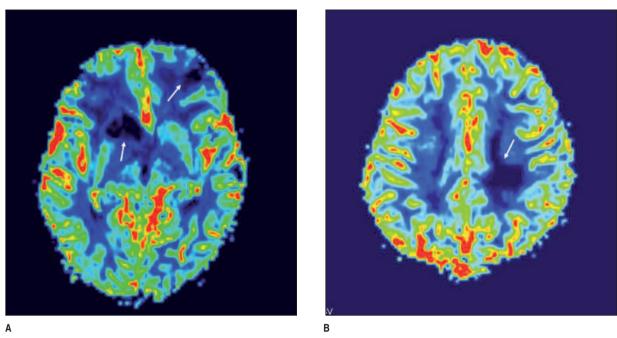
The lesions (in periventricular region) were hypovascular in perfusion MRI (CBV: cerebral blood volume images). (See for colored form http://tipbilimleri.turkiyeklinikleri.com/)
